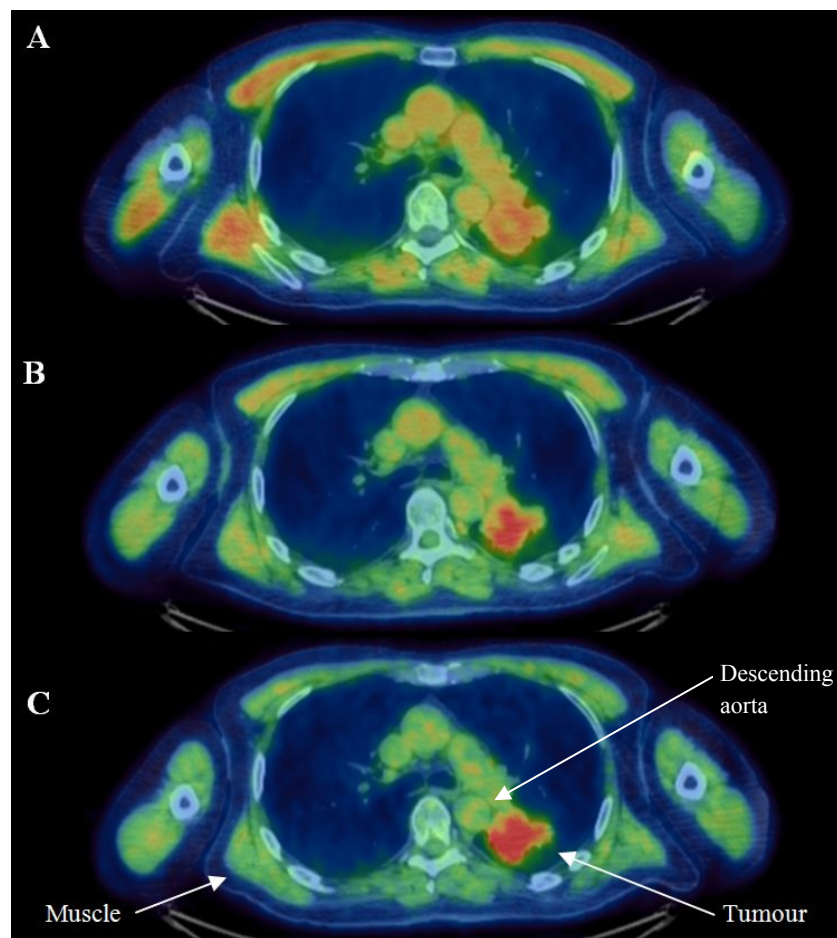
Fused FMISO images for Patient 3_{preC1} at (A) 35 mins, (B) two hours, and (C) four hours post-injection. All images are of 10 minutes duration and use an SUV scale of 0-3, such that red corresponds to SUV values greater than 3.
